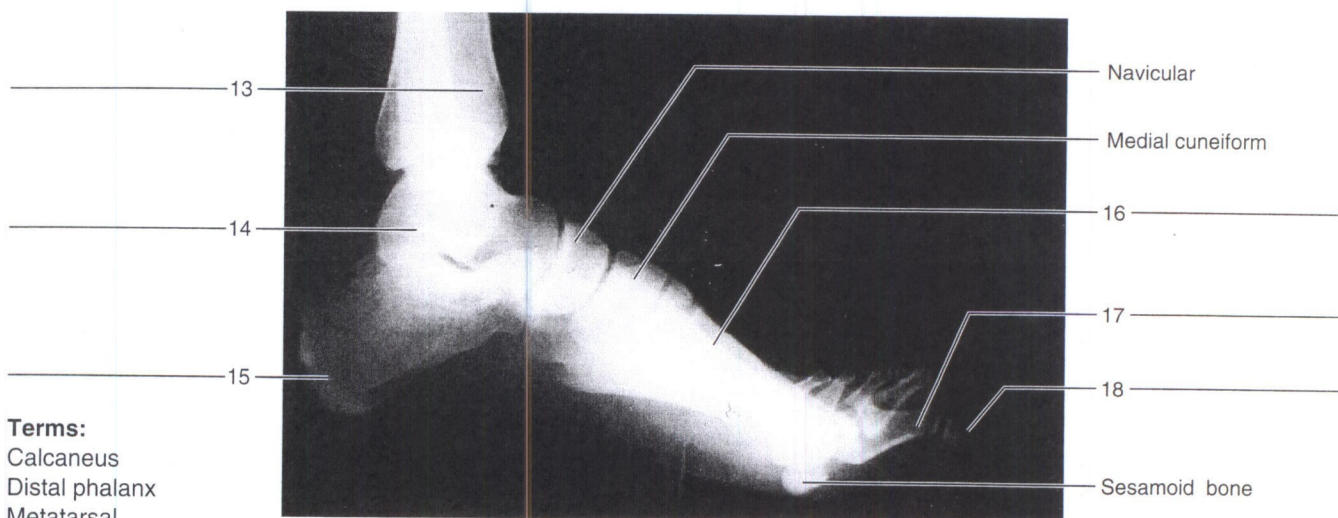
Identify the bones indicated on this radiograph of the left foot, using the terms provided.
